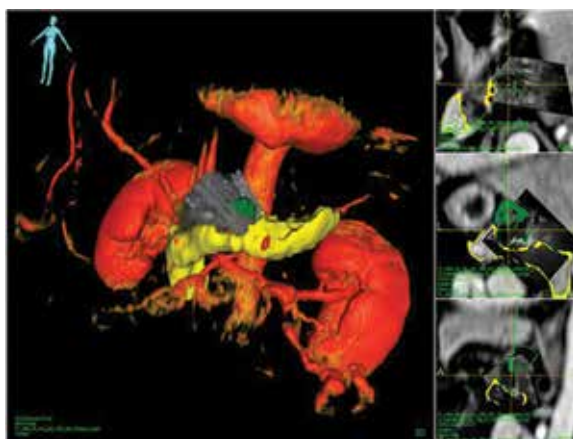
Snapshot of the CustusX platform during a distal pancreatectomy. The tumor is shown in green and the pancreas in yellow. The US imaging is superimposed on the 3D model from a preoperative MRI scan.
